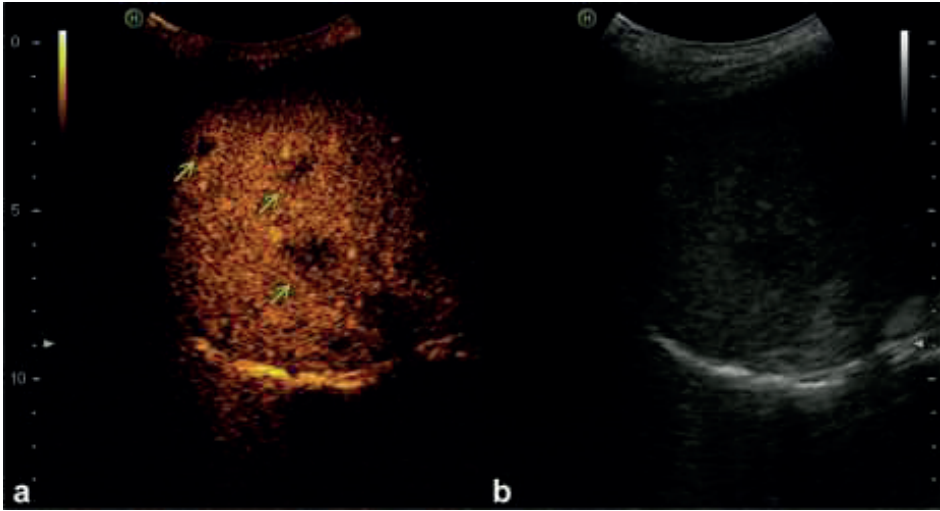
Metastases detected by contrast-enhanced ultrasound. (a) Significant washout in multiple focal lesions 83 s after contrast IV injection. (b) Control native, non-enhanced ultrasound. Liver parenchyma heterogeneity can be easily misinterpreted.
